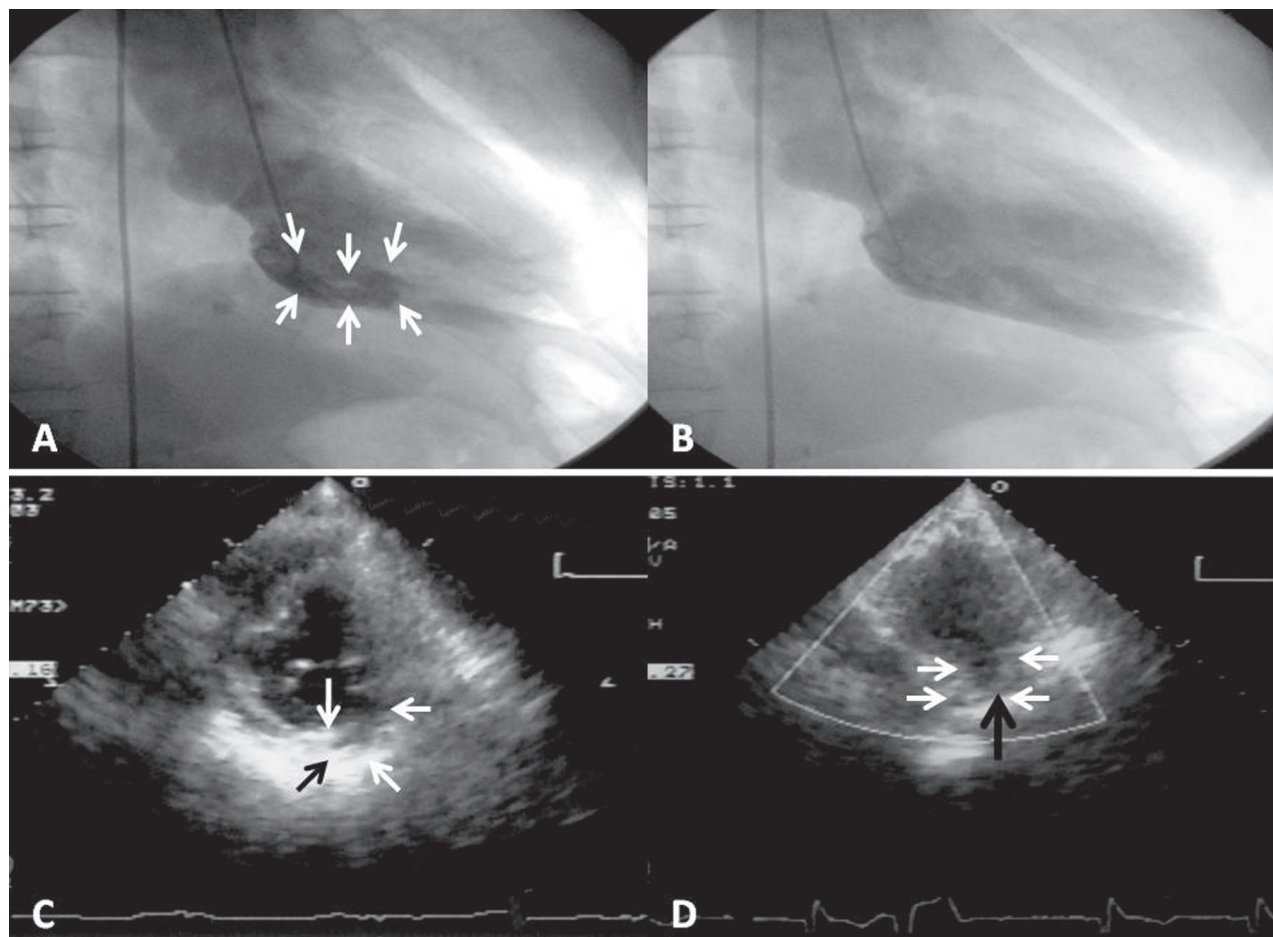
Left ventriculograms (upper panels) and the follow-up transthoracic echocardiograms (lower panels) of our patient, who developed a basal inferoposterior pseudoaneurysm after inferior myocardial infarction. Systolic (A) and diastolic (B) frames of the contrast left ventriculograms show a tubular pseudoaneurysm (arrows) in the basal inferoposterior wall. The follow-up echocardiograms (short-axis views at the papillary muscle level) in 2003 (C) and 2005 (D) reveal little change in the size of the inferoposterior pseudoaneurysm (arrows). Organized thrombi can be seen in panel D (black arrow).
